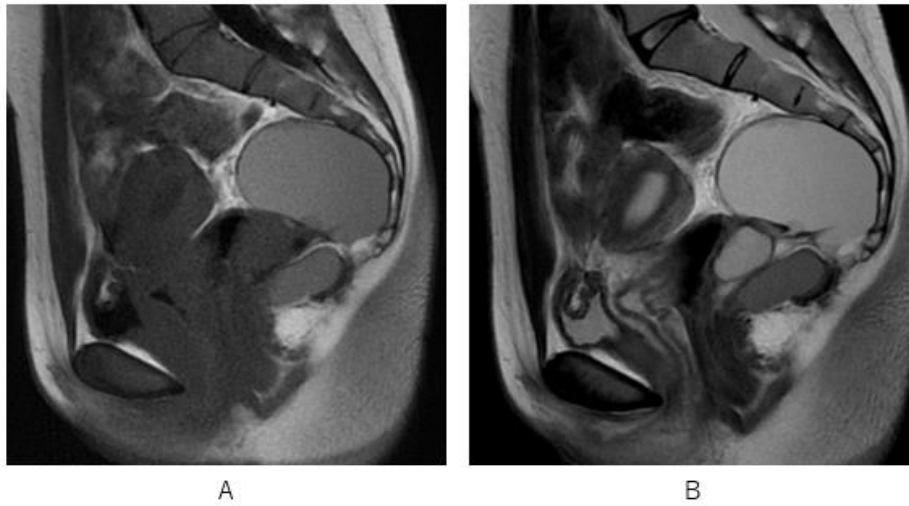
Sagittal MRI T1WI (A) and T2WI (B) depict a multi-cystic lesion between rectum and sacrum. Fluids of three cystic lesions own different signal intensity, indicative of different fluid quality.
